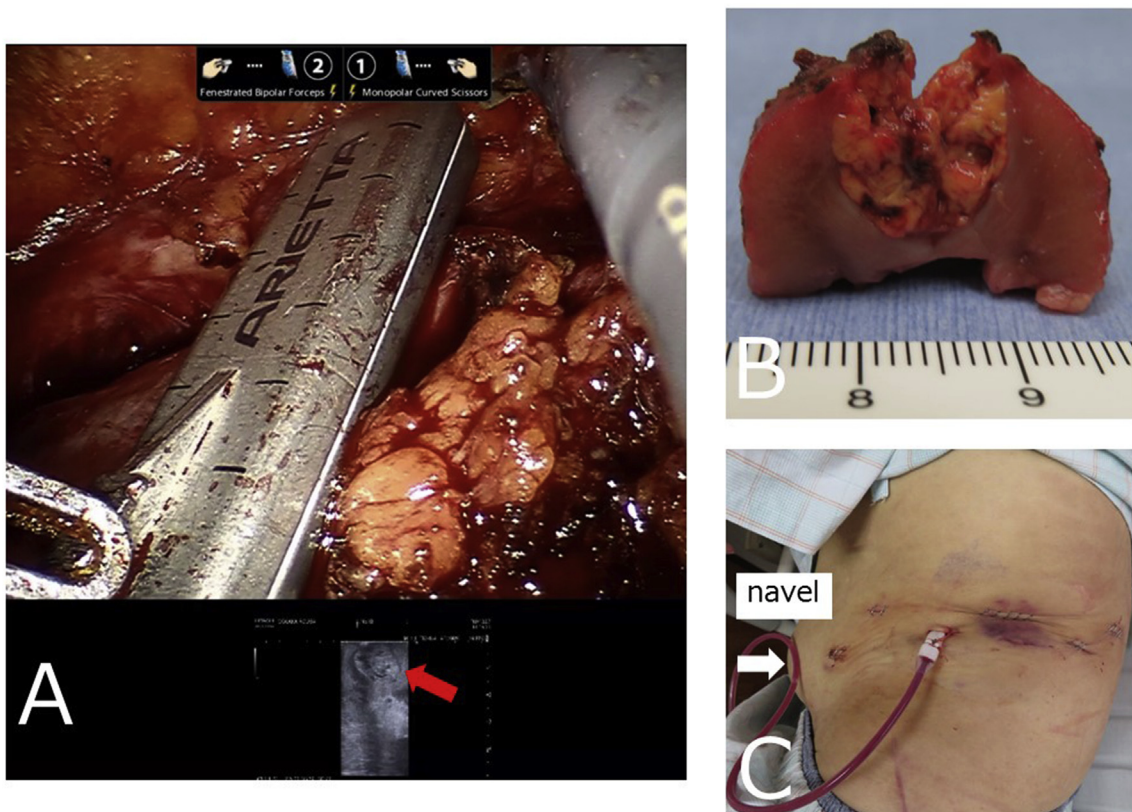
(A) Ultrasound image of renal cell carcinoma (arrow) during RAPN surgery. (B) Resected renal cell carcinoma with negative surgical margins. (C) The positions of the surgical ports and patient's wound after surgery (arrow reveals the navel).
